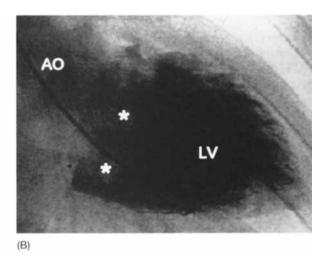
(A) Transthoracic echocardiography. Parasternal short-axis view at the level of the mitral valve demonstrating two separate mitral valve orifices. The lateral orifice was located anterior to the medial orifice. (B) Left ventricular angiography in the right anterior oblique projection revealed the two separate mitral leaflets indicated by asterisks.
